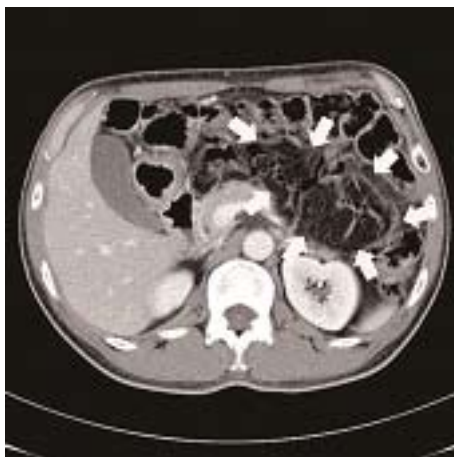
Abdominal computed tomography showed large amounts of fatty infiltration (white arrows) involving the jejunum and mesentery.
